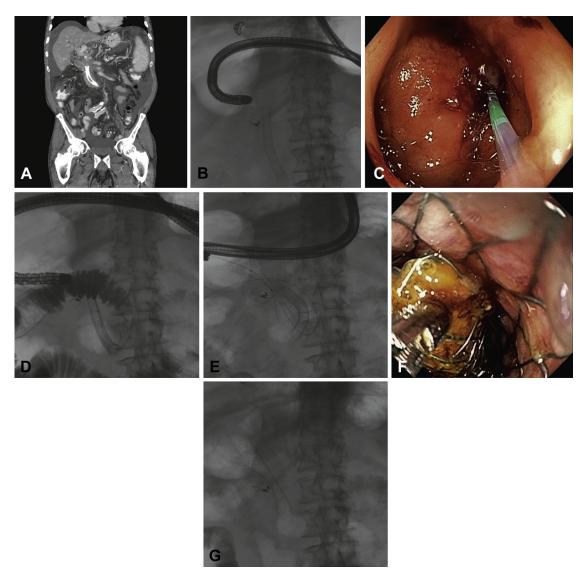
A, Coronal plane of CT view of abdomen and pelvis with and without intravenous contrast medium showing migrated biliary stent in the second to third portion of the duodenum. B, Fluoroscopic scout film of migrated biliary stent in the right upper quadrant of the abdomen. C, Endoscopic view of duodenal bulb obstruction with intubation by a tandem catheter. D, Fluoroscopic view of duodenum confirming successful passage of guidewire, intubation of duodenal stricture with a tandem catheter, and contrast medium filling the lumen adjacent to migrated biliary stent. E, Fluoroscopic view of deployed duodenal stent over duodenal stricture and adjacent migrated biliary stent. F, Endoscopic view of migrated biliary stent being removed with rattooth forceps through a deployed duodenal stent. G, Fluoroscopic view showing only duodenal stent and confirming removal of migrated biliary stent.
